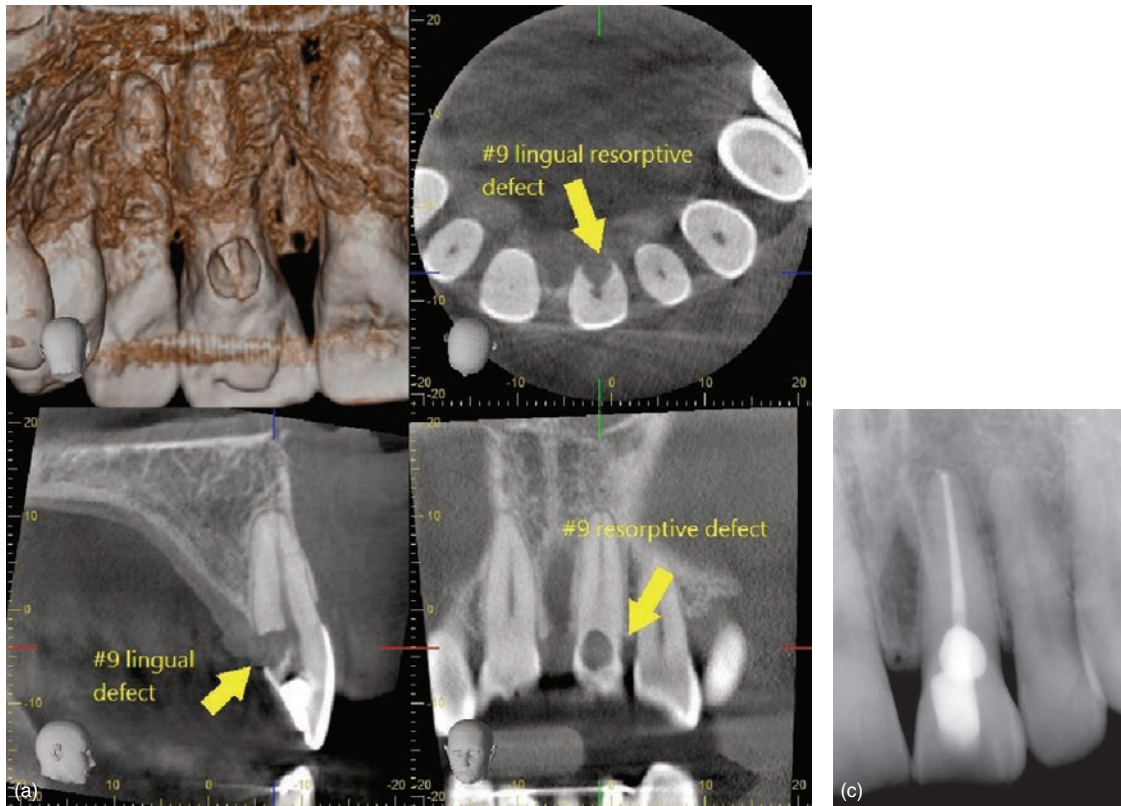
Palatal resorption. (a) CBCT images showing a maxillary incisor with palatal cervical resorption. (b) Intraoral pictures showing cervical resorptive defect and repair with Geristore. (c) Postoperative radiograph showing root canal treatment with coronal and cervical fillings.
